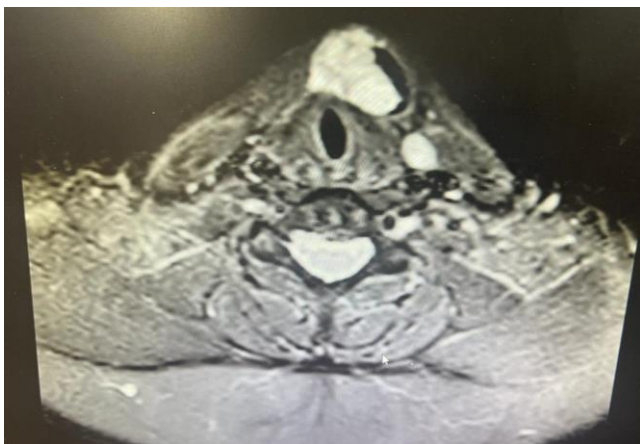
MRI Neck with contrast showing well circumscribed midline mass lesion involving visceral space of infrahyoid neck.
